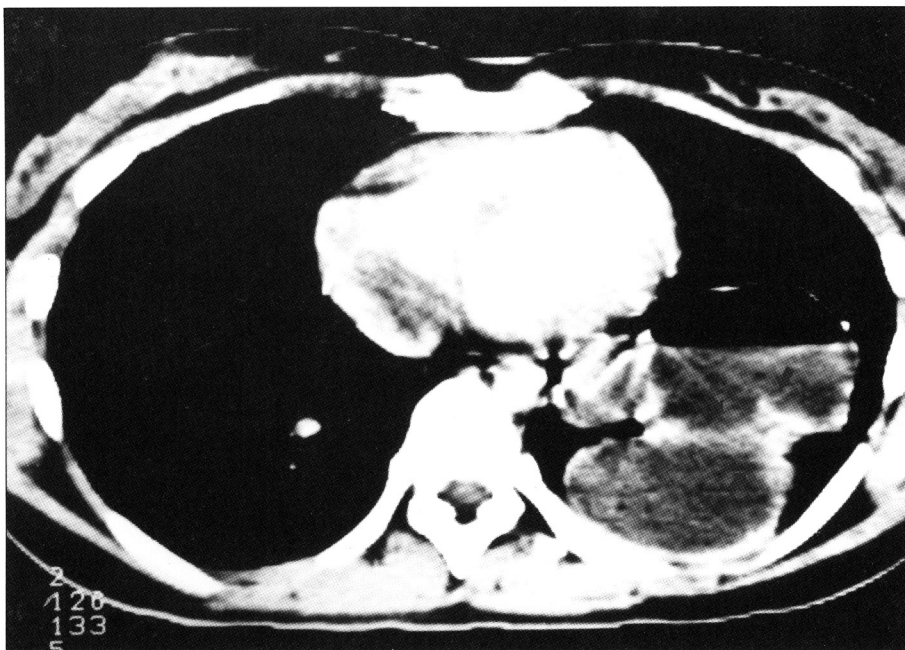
CT demonstrates multilobulated cystic lesion with air-fluid level, with thin-wall, and focal enhancing solid component(arrows).
